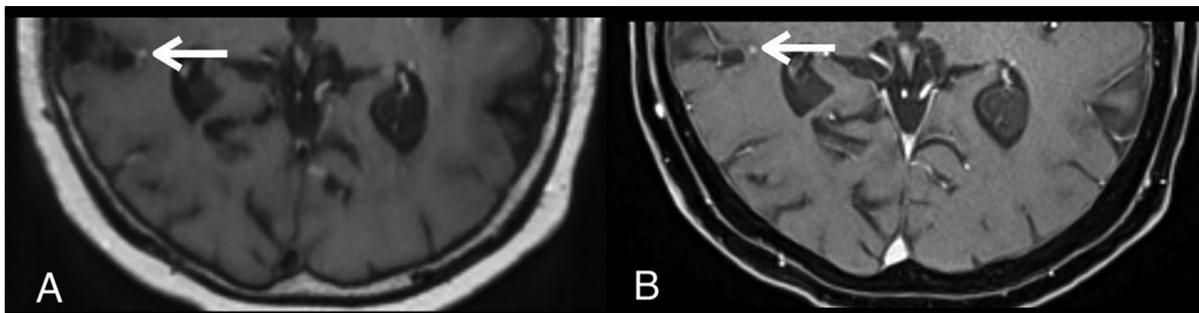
A 76-year-old lung cancer patient with a brain metastasis in the right temporal lobe (white arrow) that was missed by readers on contrast-enhanced 3D T1-weighted SPACE. Axial contrast-enhanced 3D T1-weighted SPACE (A) and contrast-enhanced 3D T1-weighted VIBE (B). The degree of enhancement is similar on both sequences. However, this lesion was missed because it located close to a vessel and was mistaken for an incompletely suppressed vascular signal on contrast-enhanced 3D T1-weighted SPACE (A). Axial contrast-enhanced 3D T1-weighted VIBE (B) clearly distinguishes parenchymal enhancing lesion and adjacent vascular structure.
